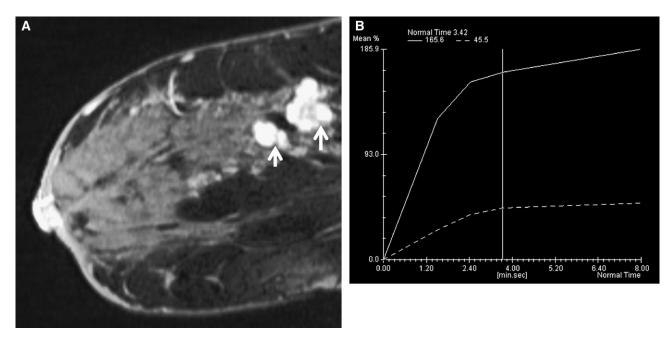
A 50-year-old woman with a lobulated mass with benign enhancement and internal nonenhancing septations on magnetic resonance imaging. (A) Sagittal contrast-enhanced T1 fat-suppressed image of the right breast, showing 2 enhancing masses at 12 o'clock, which contain nonenhancing septations within the lesions (arrows), characteristic for fibroadenomas. (B) Kinetic curve of the larger lesion, demonstrating gradual (type 1) enhancement, consistent with a benign lesion. Ultrasound biopsy confirmed the diagnosis.
